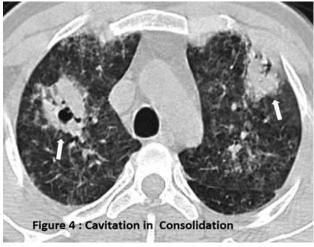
HRCT Axial image showing cavitation in consolidation
